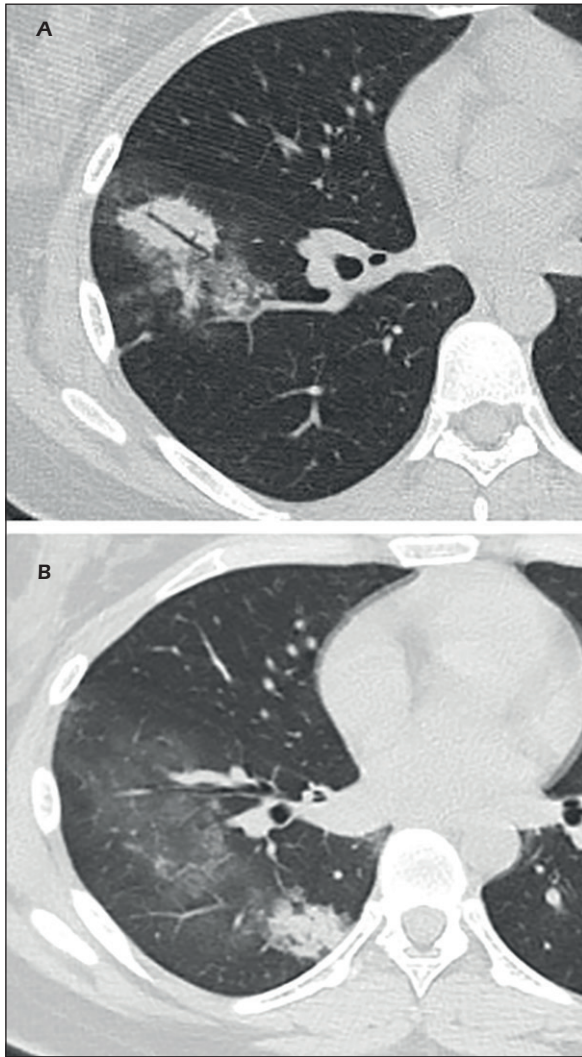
A female, 53 years old, fever for one day. Multiple nodules were found in the inferior lobe of the right lung. Cavitary shadows were seen in the subpleural nodule, and the edge was smooth. The CT result taken less than four days later was negative for the patient.
